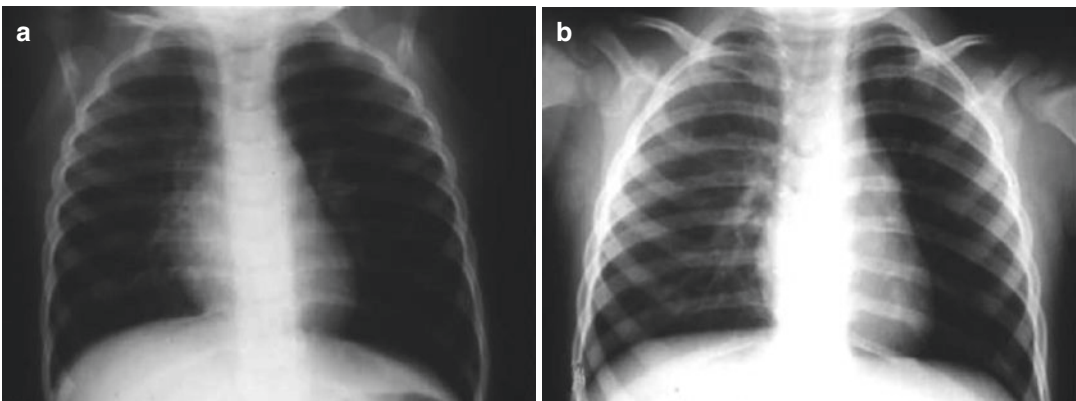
Lung hyperinflation. Anteroposterior chest x-rays of a 4-year-old child during inhalation (a) and during exhalation, showing hyperinflation of the left hemithorax (b)
